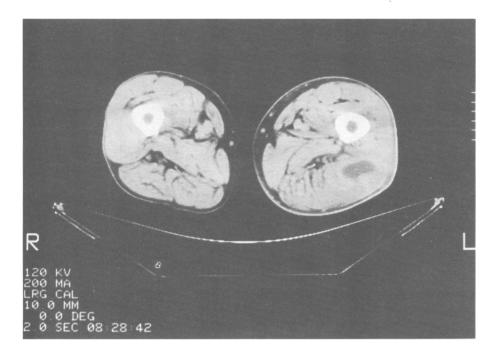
A computed tomographic scan shows pyomyositis in the long head of the left biceps femoris (patient 4).
